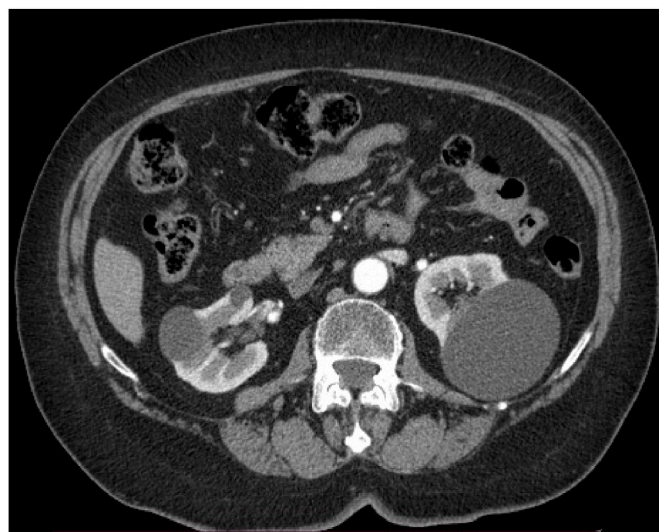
Abdomen computed tomography shows multiple different size kidney cysts.
